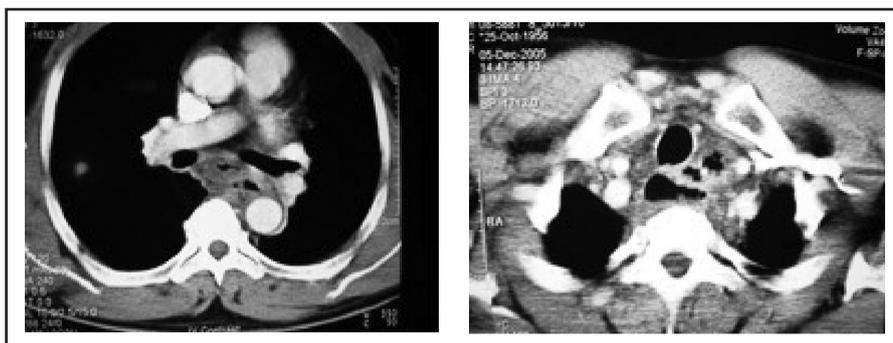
CT scans of the root of the neck and thorax reveals peri-esophageal soft tissue edema with air-fluid cavities.
